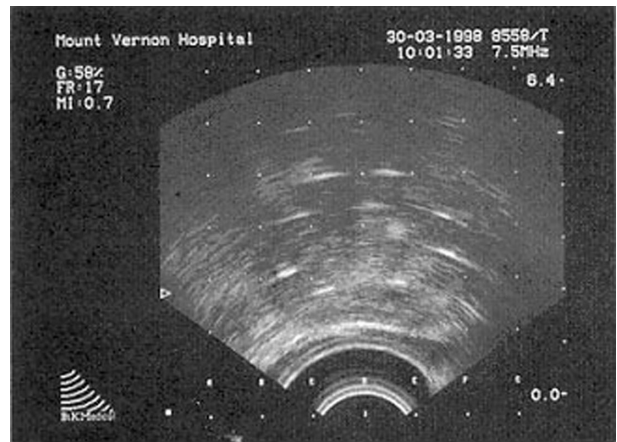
Transverse ultrasound image
